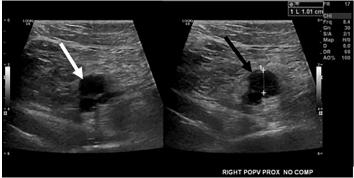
Ultrasound image of the popliteal vein on the right side without compression (white arrow) and with compression (black arrow). The popliteal vein was uncompressible, consistent with a venous thrombosis.
